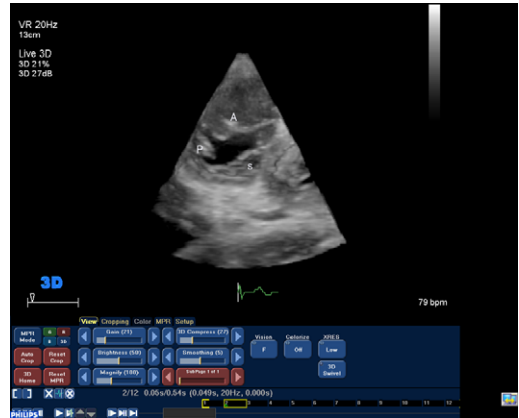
The tricuspid valve obtained from the parasternal short axis view with tilting toward the right. Electronic beam steering was employed to optimize the image (case 3).
